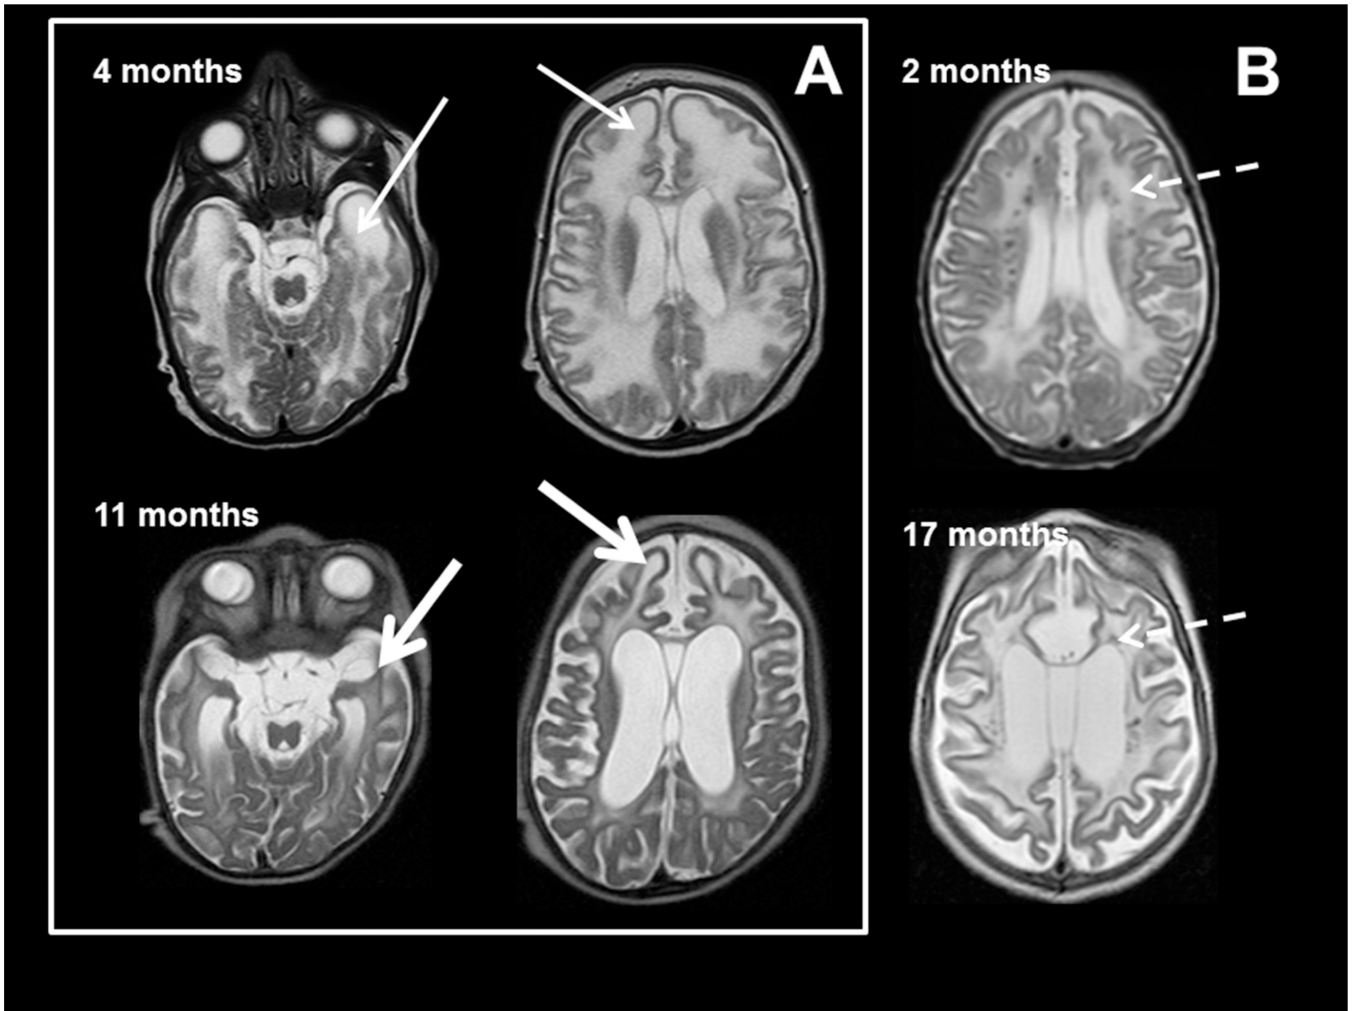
MRI characteristics in AGS
